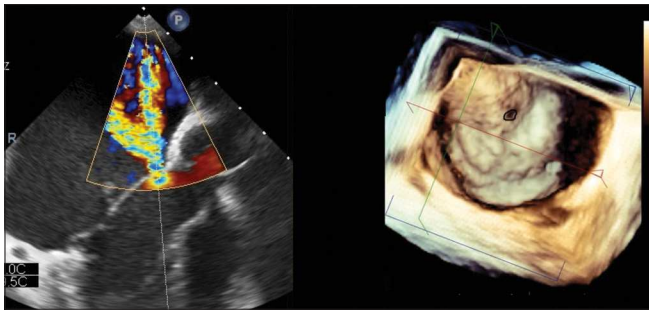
Transesophageal echocardiography: The procedure revealed a moderate size regurgitation (left) and a circular defect on three-dimensional reconstruction (right)
